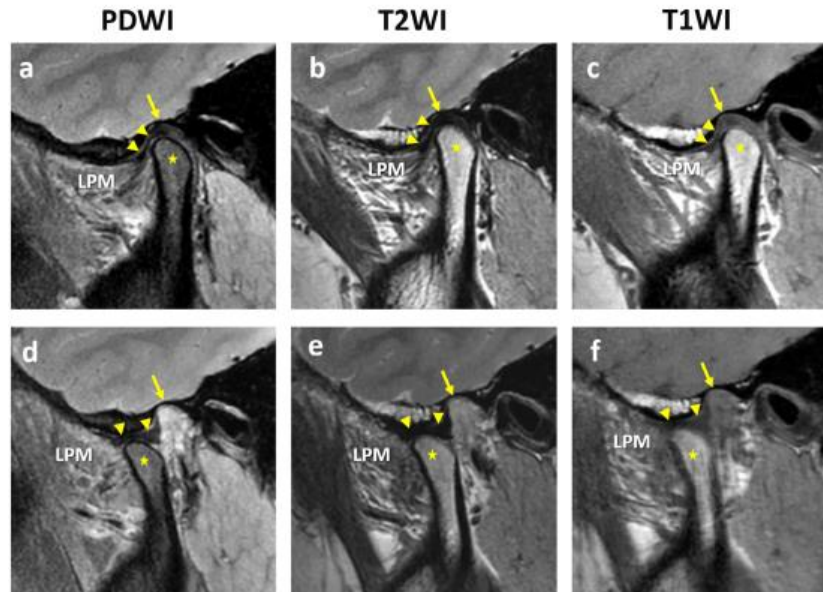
Conventional MRI of normal TMJ in (a–c) closed-mouth position and (d–f) open-mouth position, showing the static anatomy of TMJ and related muscles, including TMJ disc (triangle), mandibular fossa (arrow), mandibular condyle (star), and lateral pterygoid muscle (LPM)
